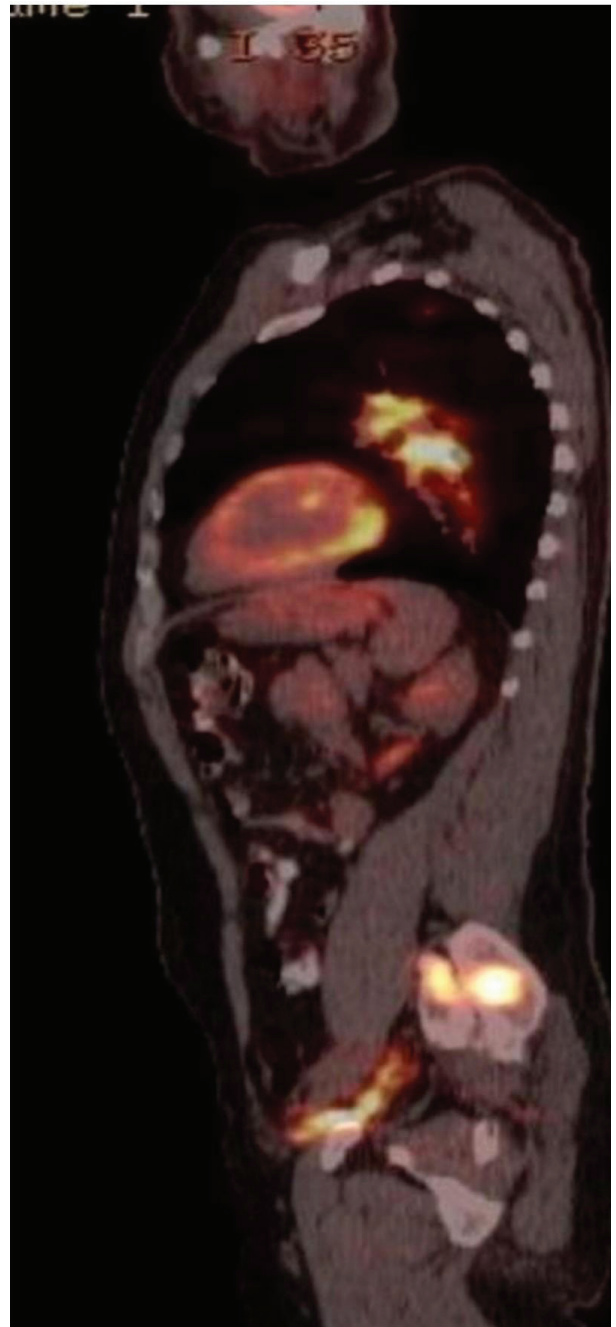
Pelvic bone involvement with 11.8 mSUV
